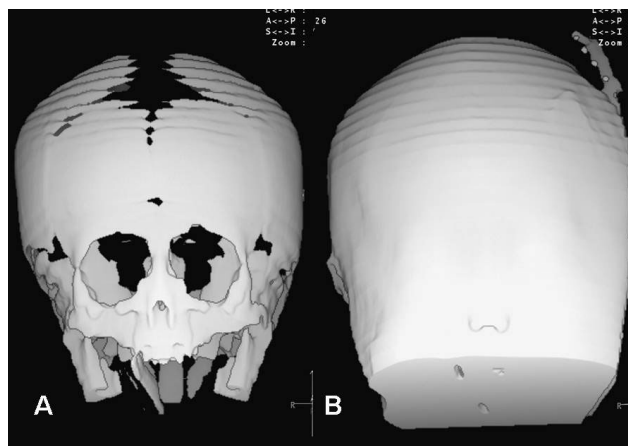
Three-dimensional CT of the anterior (A) and posterior (B) skull showed hypotelorism and premature synostosis of all of the cranial sutures except for the sagittal suture.
